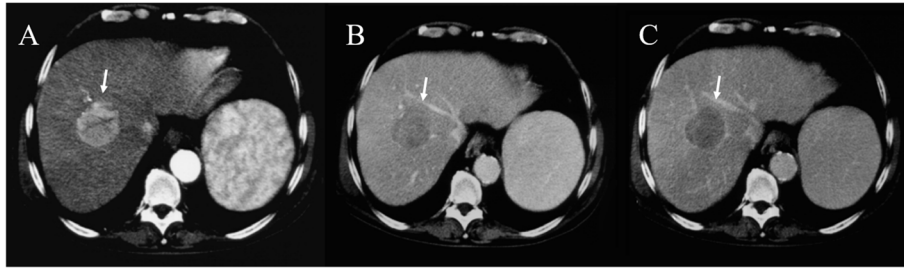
The same case of Fig. 4. CT assessment. During contrast study, the lesion (arrow) shows hyperenhancement during arterial phase (A), wash out during portal (B) and equilibrium (C) phase
